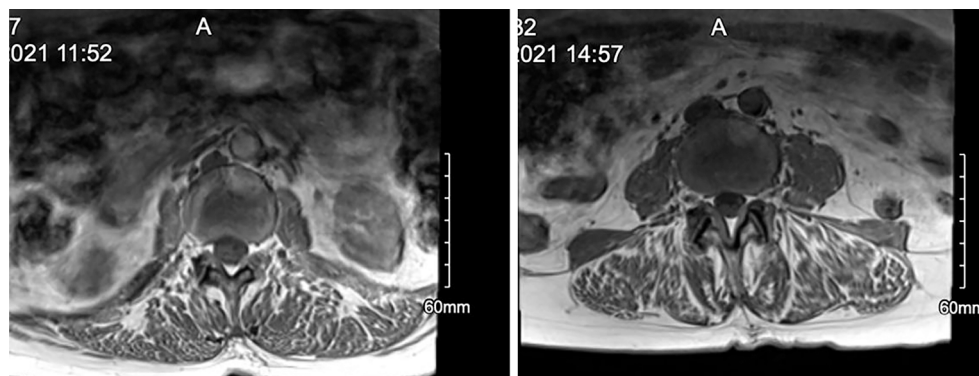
Partial response in sclerotic lesion of lumbar spine. Left panel: January 2021 MRI status post cycle 4. Right panel: July 2021 MRI status post cycle 11 with continued partial response.
